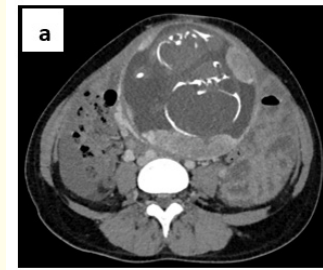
a, b and c. Axial, sagittal and coronal contrast-enhanced CT scan images showing an ectopic pregnancy, located above the uterine corpus, and abundant hemoperitoneum.
